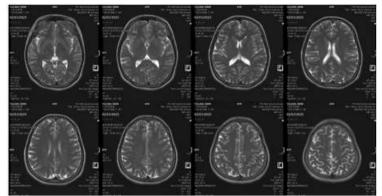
MRI test with contrast 2 weeks after preterm delivery
